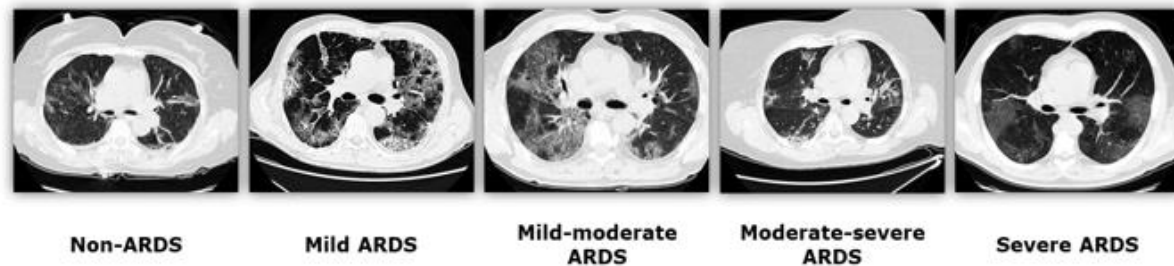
lung Computed Tomography (2-3 cm below the carina) extracted randomly from the non-ARDS, mild ARDS, mild-moderate ARDS, moderate-severe ARDS and severe ARDS. As shown, it is hard to find a relationship between the severity of the imaging and the severity of the hypoxemia.
